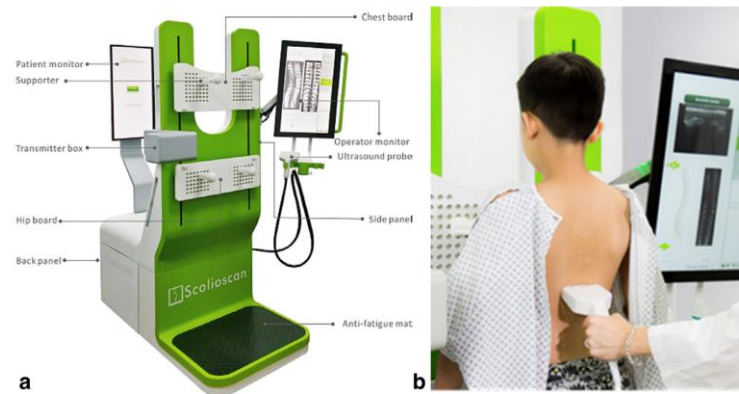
(a) The Scolioscan (b) Ultrasound assessment for a patient (Wong *et al.*, 2019).
